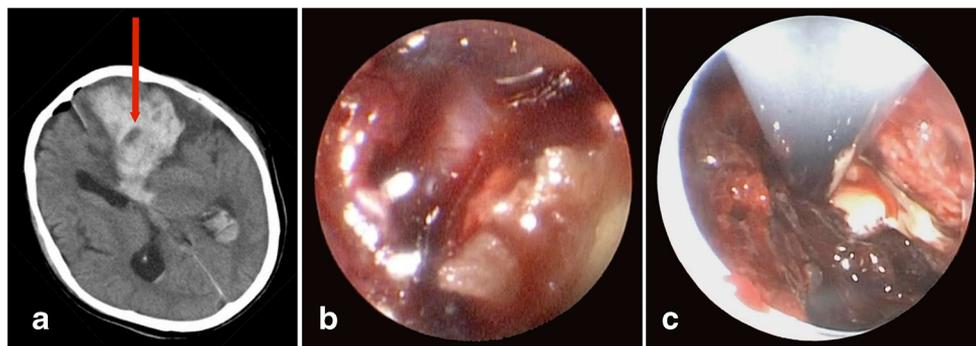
CT scan and intraoperative endoscopic views of case 8, an 85-year-old man. a The red arrow indicates the planned trajectory for neuro-endoscopic aspiration, targeting the blood-fluid interface in the cerebral contusion. b Edematous brain surface observed from the burr hole. c
